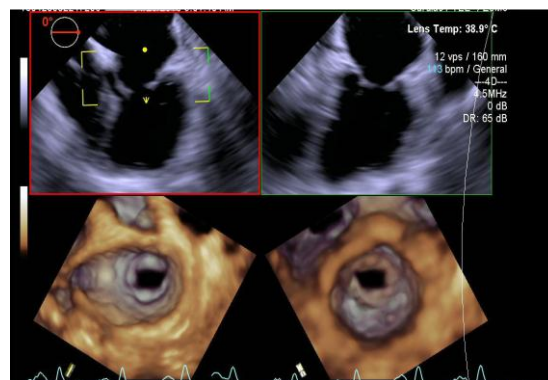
Trans esophageal echocardiography severe MS
